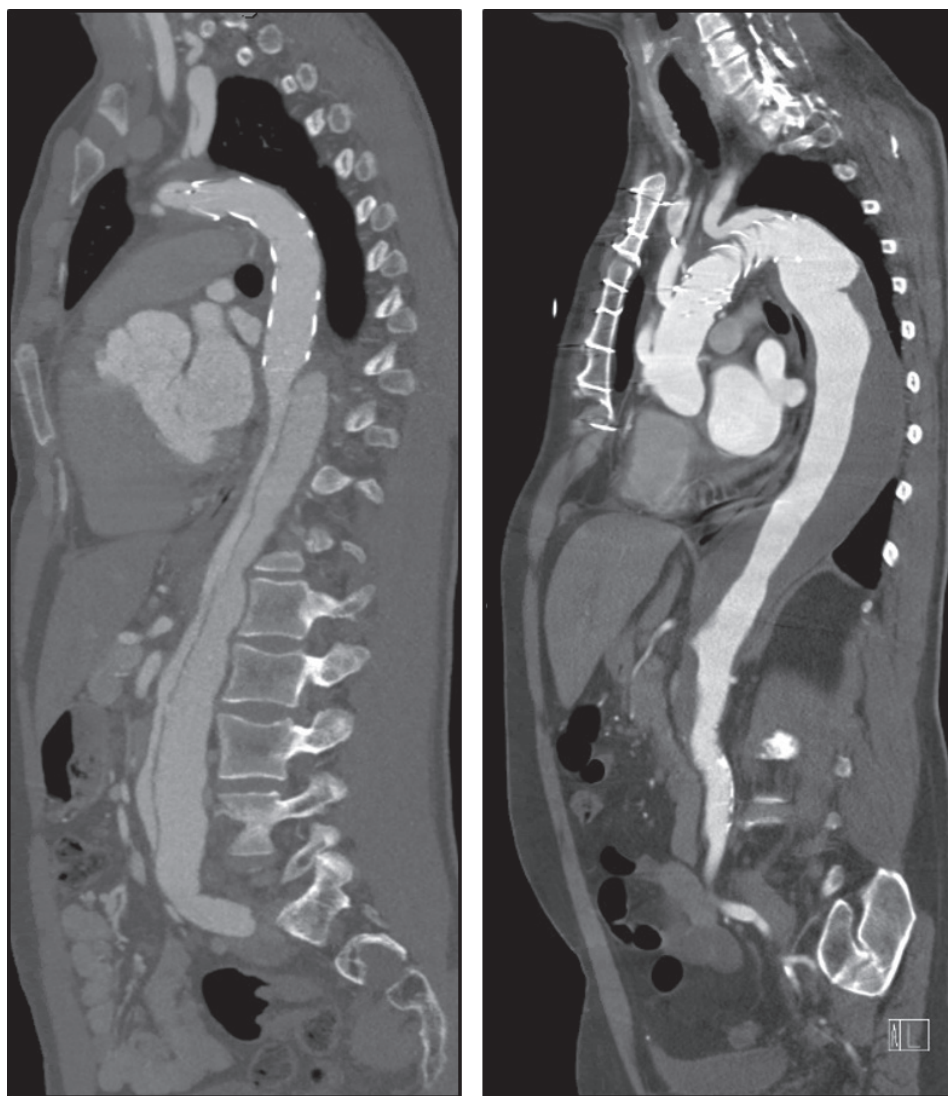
CT scan after open ascending aorta repair including frozen elephant trunk.
